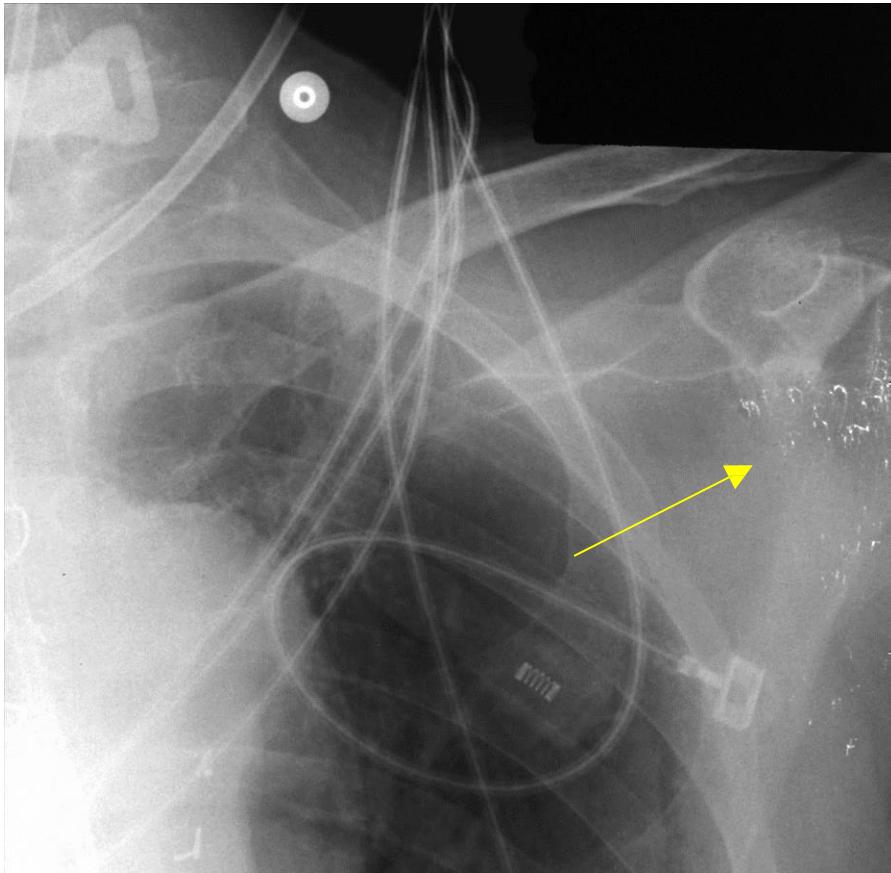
Image from: Cesar LJ et al, 2001, Artifacts found in computed radiography, BJR 74: 195-202.
